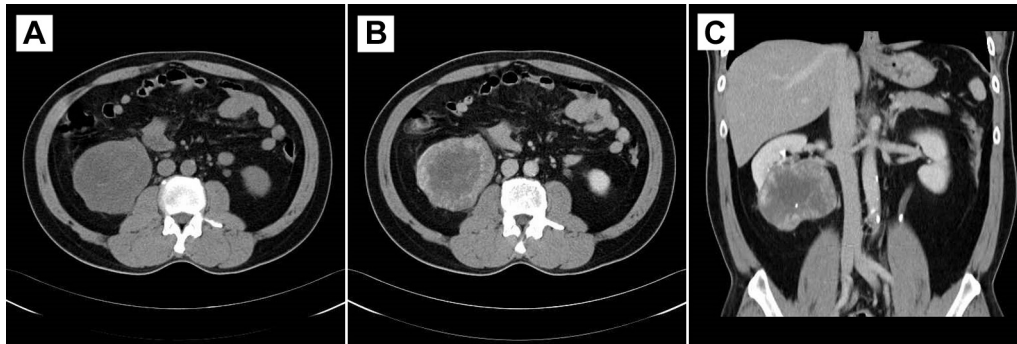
Renal leiomyoma. (A) Axial noncontrast computed tomography reveals a protruding mass measuring 7.8 cm × 7.4 cm × 7 cm in size in the lower pole of the right kidney, which shows a central low density and irregular marginal high density. (B) Axial and (C) coronal contrast-enhanced computed tomography reveals marginal contrast enhancement and central low density of this tumor.
